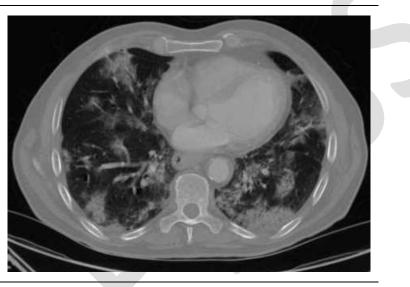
The Chest computed tomography (CT) scan showed ground-glass opacity in both lungs, highly suggestive for COVID-19 pneumonia
